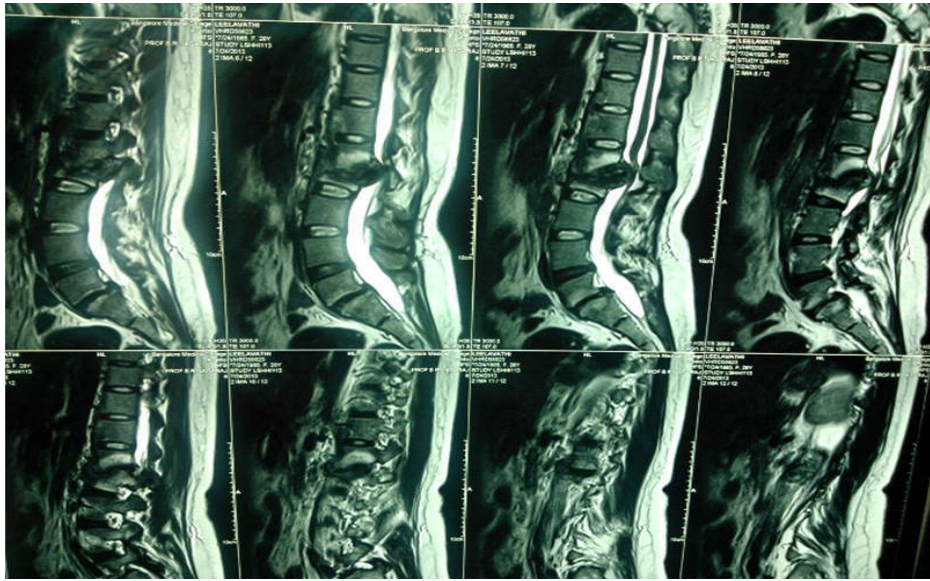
Shows MRI T2WI L2 Potts spine preoperative
